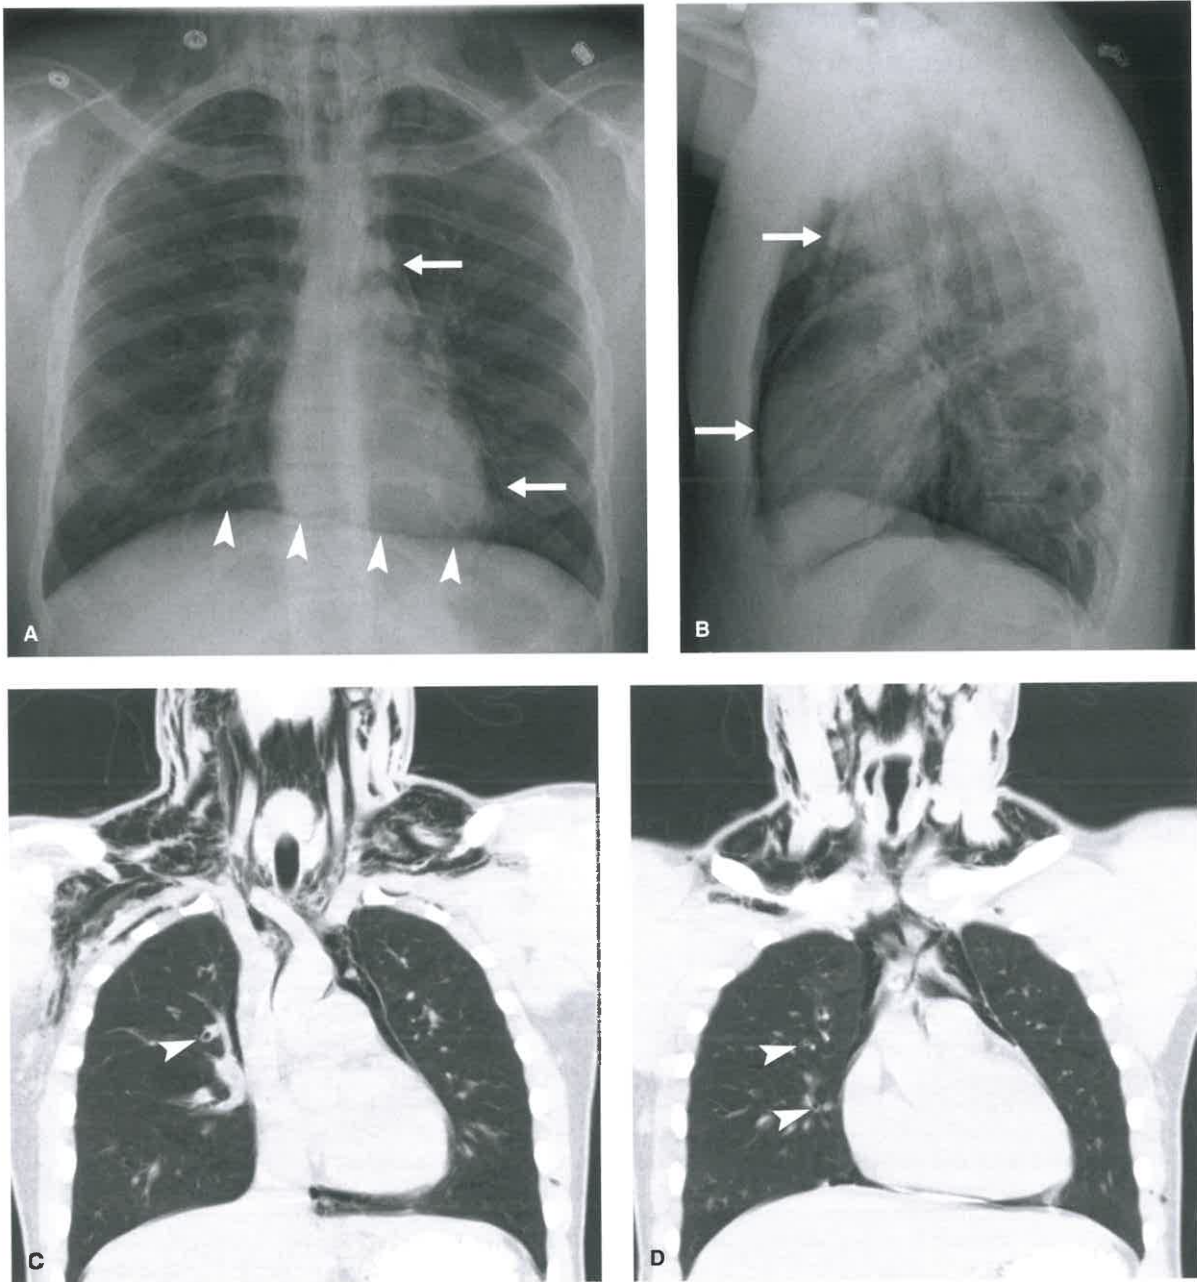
Pneumomediastinum. A, B: Frontal (A) and lateral (B) chest radiographs in a patient with an acute asthma exacerbation shows perihilar bronchial cuffing (*arrow*) and pneumomediastinum extending into the neck producing subcutaneous emphysema. Note the ability to see the diaphragm as a continuous interface (“continuous diaphragm” sign) (*arrowheads*). C, D: Coronal CT scans at the level of the ascending aorta show airways thickening (*arrow*) and confirms pneumomediastinum extending into the neck.
